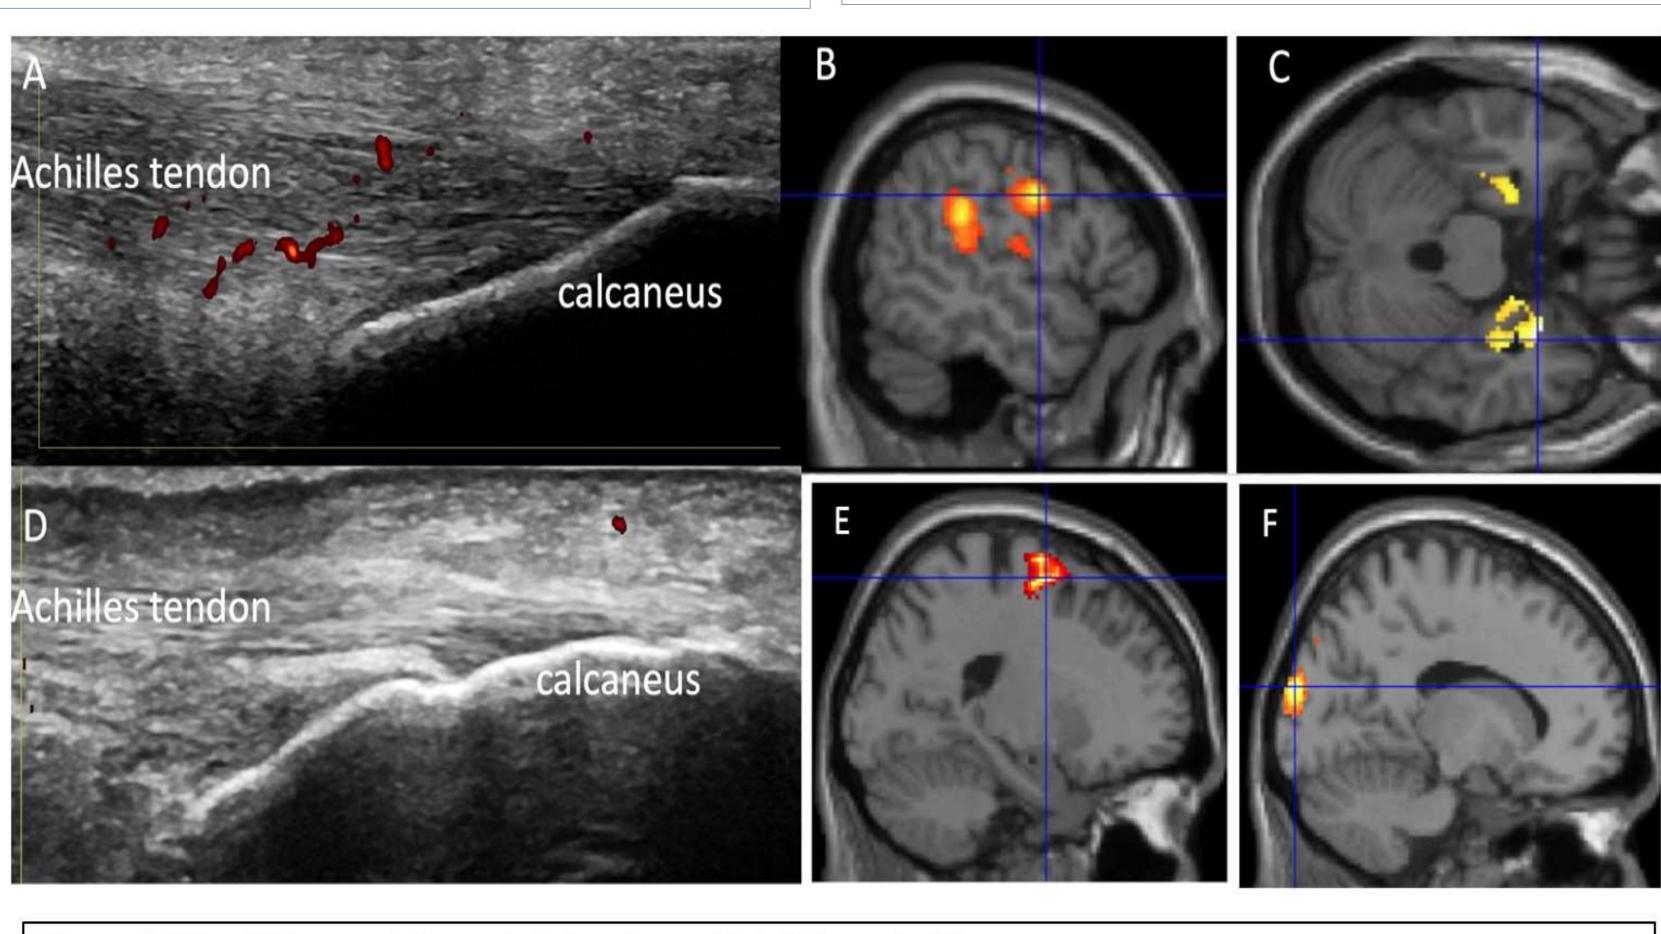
fMRI and Ultrasound Images in PsA patients with Achilles enthesitis
